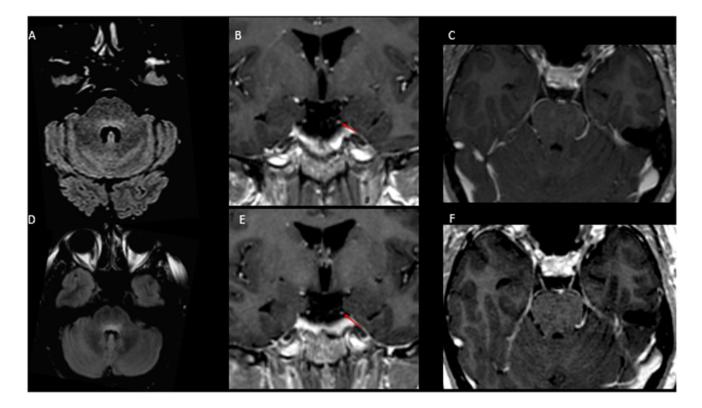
Case 2. Brainstem encephalitis associated with anti-Ma2 abs and testicular seminoma. MRI showing a smooth long TR hyperintensity in the pontine tegmentum, with axial FLAIR A; T1-weighted contrast enhancement of both oculomotor nerves B, coronal plane; C, axial plane). Repeated MRI showed the long TR hyperintensity
